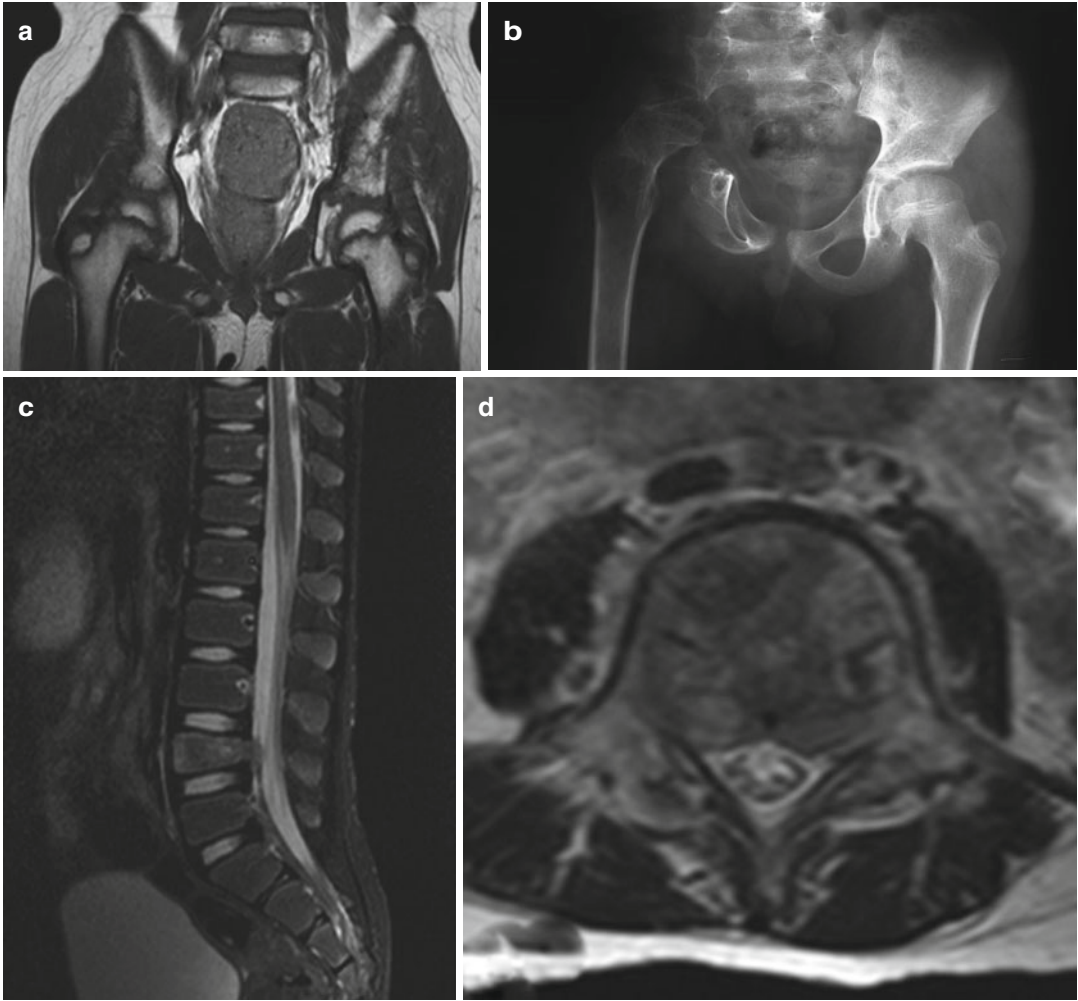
An 8-year-old male presenting with right-sided hip and buttock pain. (a) T1-weighted MR image demonstrating a mass located at the iliac wing, infiltrating the surrounding muscle. Oncologically staged as IIB, biopsy revealed a Ewing's Sarcoma. (b) Plain AP pelvis view following wide excision of the tumor after neoadjuvant chemotherapy. Developed mild back pain 1 year after index surgery. (c-d) Lateral plain X-ray and STIR axial and sagittal MR images demonstrating metastatic lesion at L4. Oncological staging III, surgical (WBB) staging zones 4-9, B and C. Patient was not referred to surgery at this
